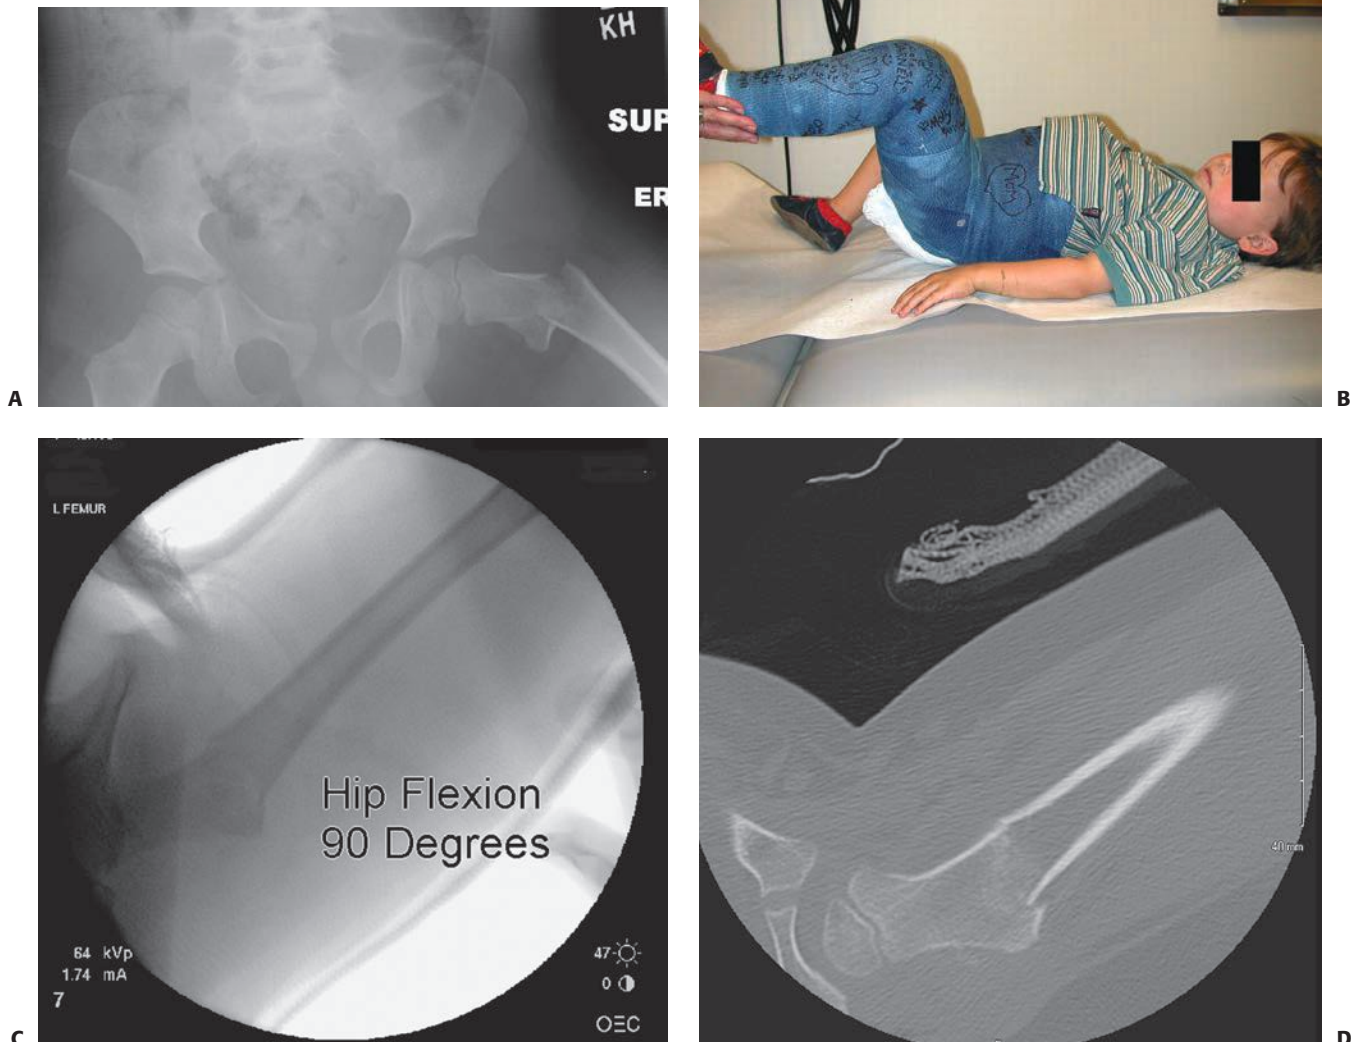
A: A 4-year-old boy fell from his window, causing a displaced type IV fracture. B: Positioning of the hip in a spica cast is usually in hip flexion and confirmed under fluoroscopy. C: Fluoroscopic radiographs in 90 degrees of hip flexion insure anatomic correctness. D: At 1-week follow-up, radiographs were inconclusive; a CT scan assists in confirming location.
